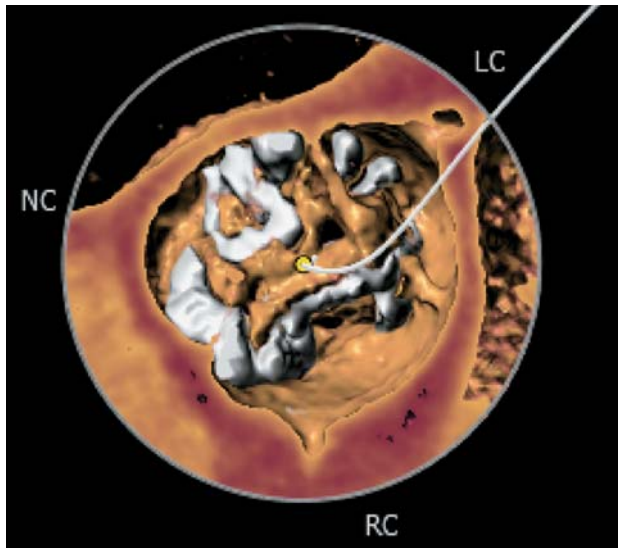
3D reconstruction using multispiral computed tomography. VRT-section at the level of aortic valve annulus in the axial plane. Degree 2–3 marked calcinosis of aortic valve cusps is observed.
